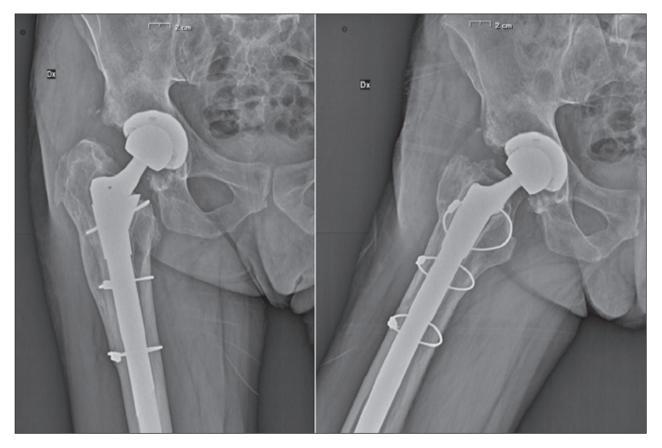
Postoperative x-ray after partial component hip revision, including replacement of the polyethylene acetabular liner and a BIOLOX delta femoral head with a BioBall adapter
